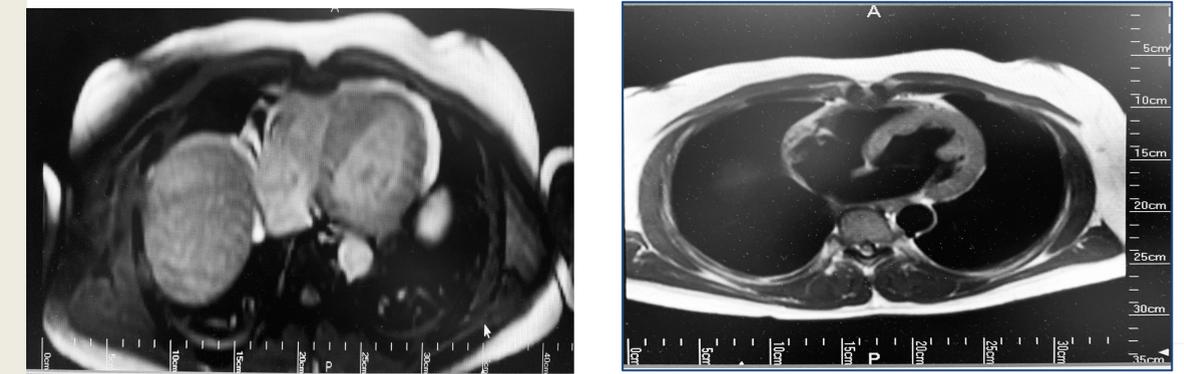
Cardiac MRI showing growth suggestive of sarcoidosis along the LV wall
